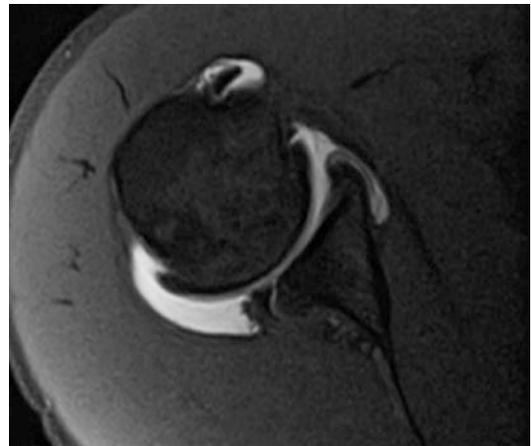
Axial MRI demonstrating mild posterior subluxation with a large posterior labral tear
